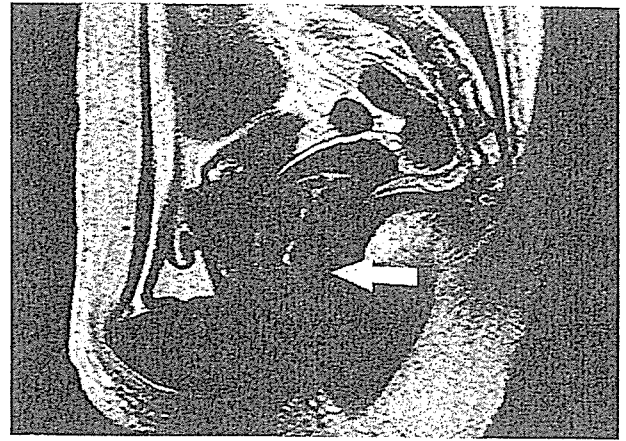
Sagittal T2-weighted image demonstrated the irregularity of the border between the advancing edge of the tumor and the external anal sphincter muscle. (arrow)
